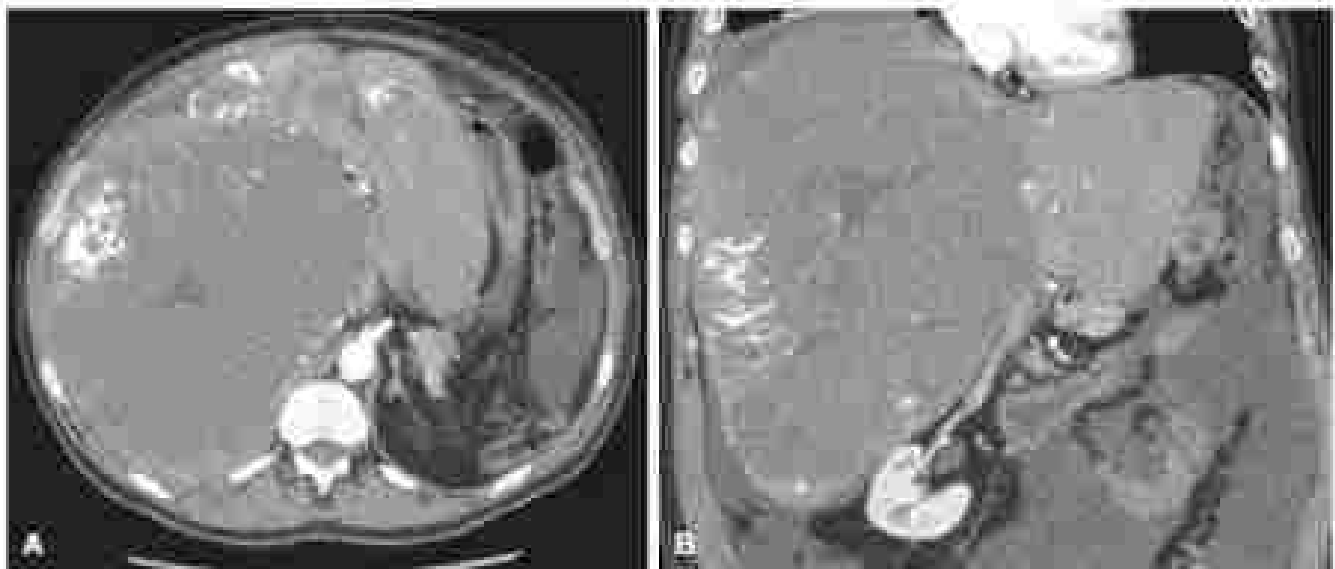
Computed tomography of a 57-year-old male demonstrating a giant hepatic hemangioma in the right lobe of the liver. Axial (A) and coronal (B) view. The patient was initially managed via conservative treatment; however, the tumor grew and hepatic artery embolization was performed at an outside institution. Subsequently, he developed ongoing bilateral pleural effusions and ascites. He is being followed at T1 intervals with fluid every 4 to 5 days. Additionally, he had lower extremity edema and pulmonary edema.
